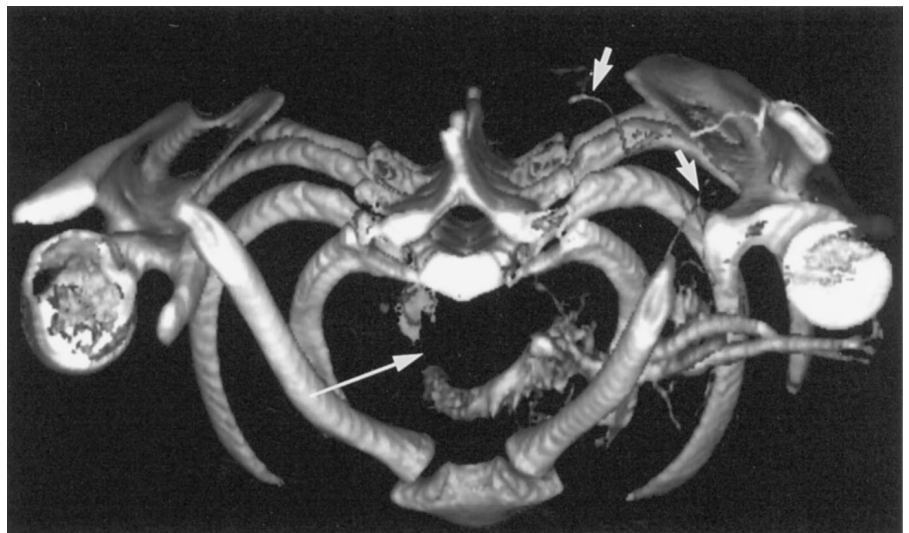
CT angiogram of the deep venous system of the left upper extremity. The image is oriented in the anteroposterior projection with mild caudal rotation. There is marked irregular narrowing of the left subclavian vein (arrow) with numerous venous collaterals around the left shoulder and to the vertebral plexus (arrow-heads).
